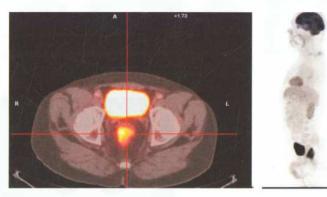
Carcinoma rectum—PET-CT scan
